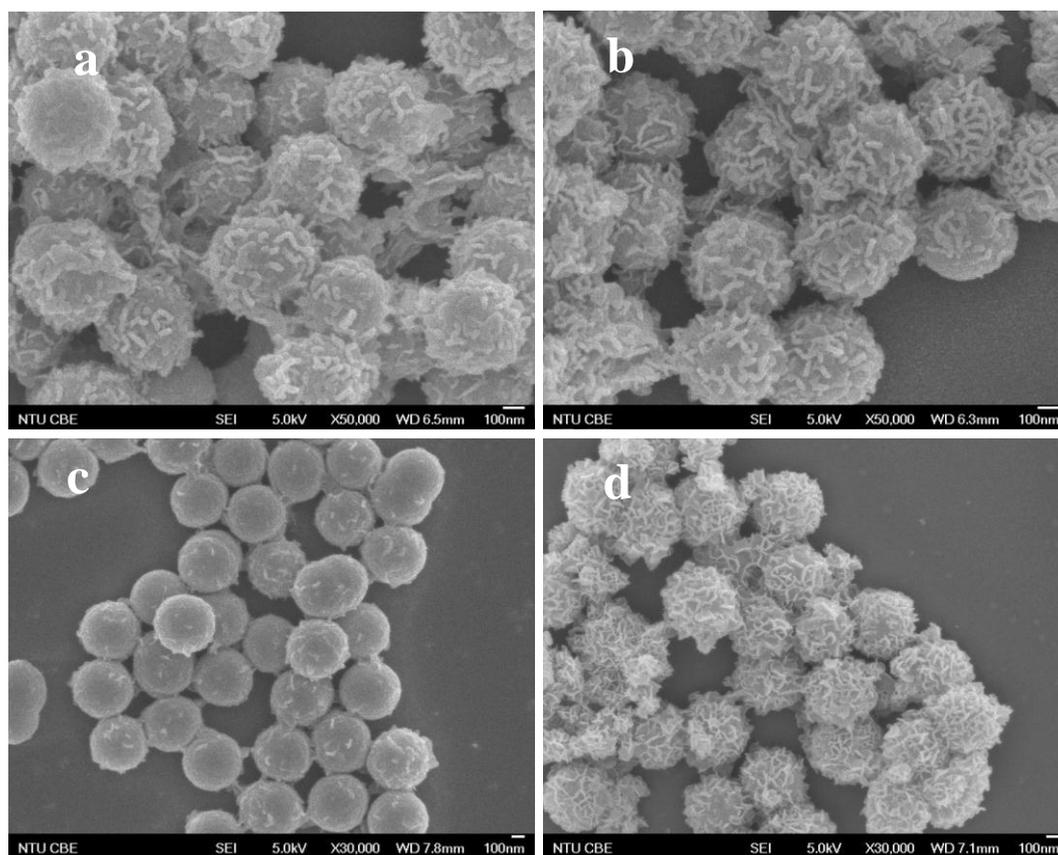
FESEM image of LDH precursors deposited on SiO<sub>2</sub> after precipitation before ultrasound treatment.
